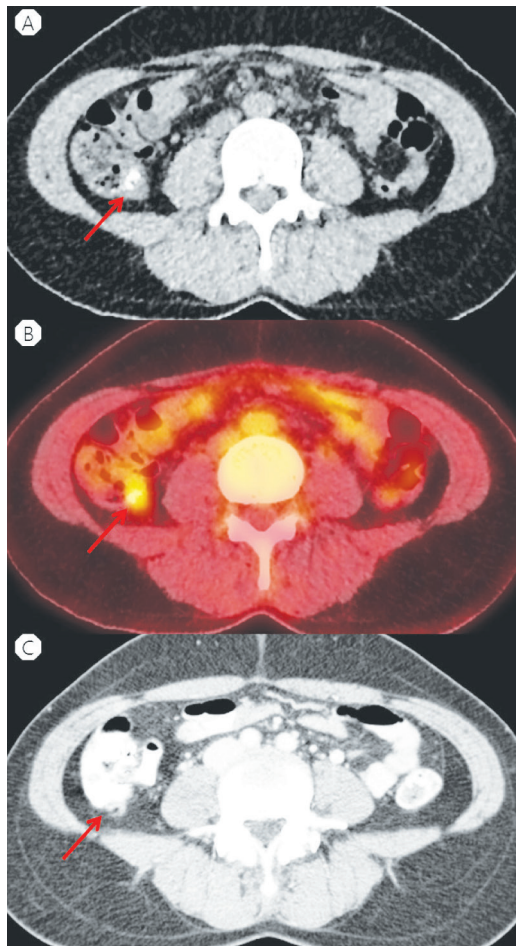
CT and PET scan of case 1. (A) On the non-enhanced CT scan, focal hyperdensity (arrow) is noted at the ostium of the appendix, probably representing calcification or ossification. (B) On the PET-CT scan, abnormally increased metabolism is noted in the hyperdensity region (arrow). (C) On the contrast enhanced CT scan, no definite enhancing lesion is noted at this area (arrow).
